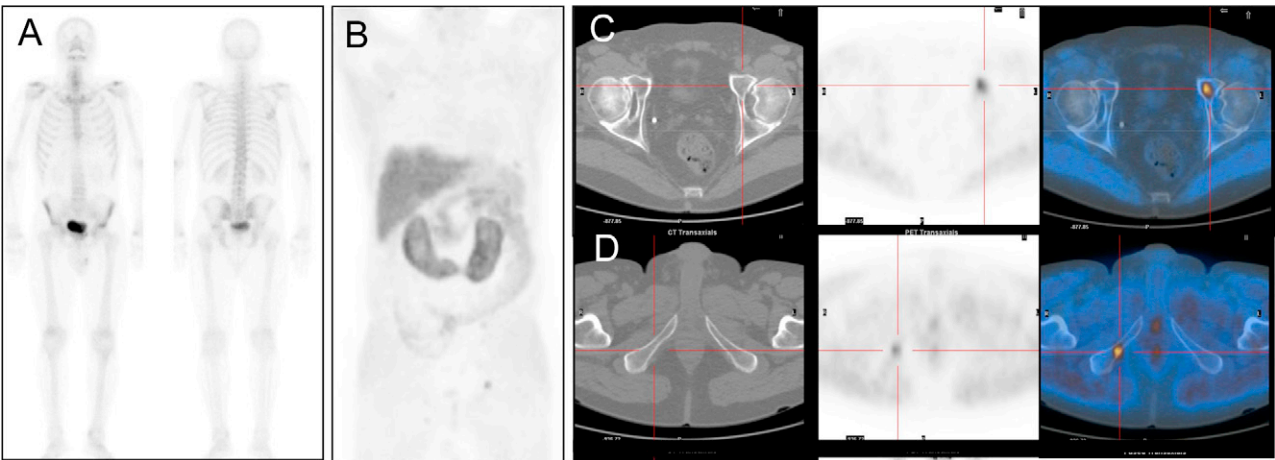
Patient # 9. Seventy-nine-years old patients; RP in 2008; pT3bN0Mx; PSA value at the time of BS study 3.55 ng/mL. BS resulted to be negative (A). ¹¹C-choline PET/CT (B) performed one month after BS showed bone metastasis in the left pubic bone, proximal to acetabulum (C), and a bone metastasis in the right ischium (D). In the MIP projection (A) it is possible to note other small areas of increased uptake in the left iliac bone and in two ribs bilaterally. To note the absence of any structural alteration at CT attenuation correction images.
